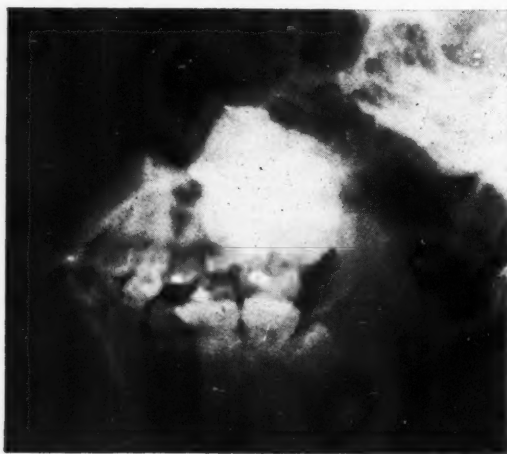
Lateral extraoral roentgenogram showing radiopaque object.
